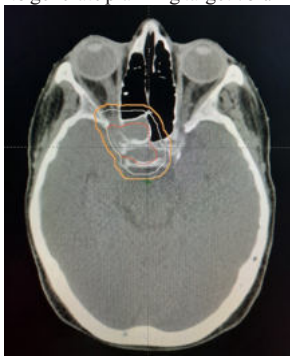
Axial CT-scan image from treatment planning system, showing delineation of Gross Target Volume (red), Clinical Target Volume (cyan), Planning Target Volume (green).
